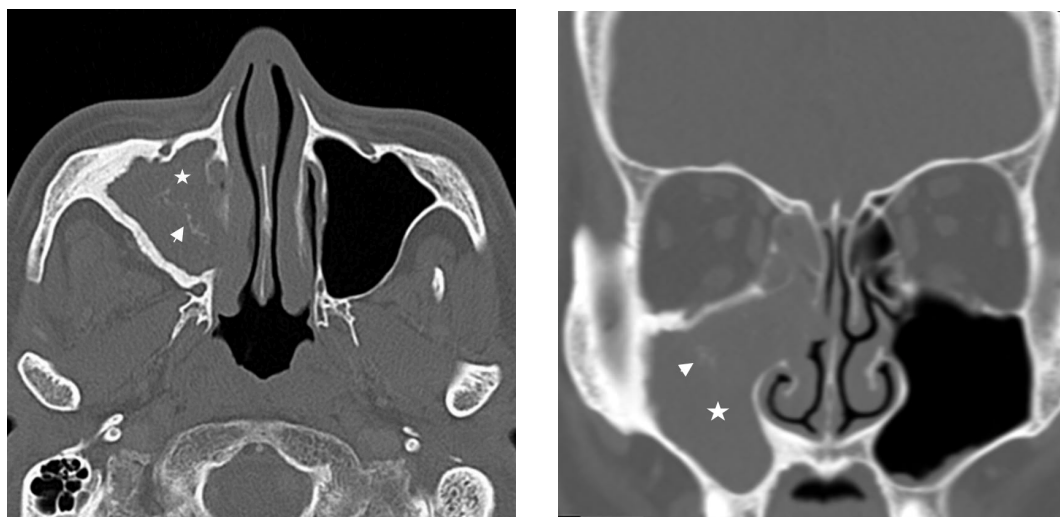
Axial and coronal computed tomography (CT) scans showing heterogeneous mass (white star) with calcifications (white arrow) within the right maxillary sinus, a characteristic of fungal ball. Erosions of the bony medial maxillary wall and nasolacrimal duct and sclerosis of the right anterior and lateral wall of the maxillary sinus can also be visualised, indicating chronic infection.
